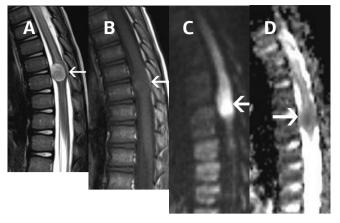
Intramedullary epidermoid cysts. A 3-year-old male patient who presented with bilateral lower extremity weakness for 4 days. MRI of the thoracolumbar spine shows an intramedullary mass at the T8-9 level. On sagittal T2-weighted image (A), the intramedullary lesion appeared hyperintense and well-defined (arrow). Sagittal T1-weighted image(B) lesion hypointense (arrow). On sagittal DWI (C), a marked high signal with low apparent diffusion coefficient value (D) is demonstrated.
